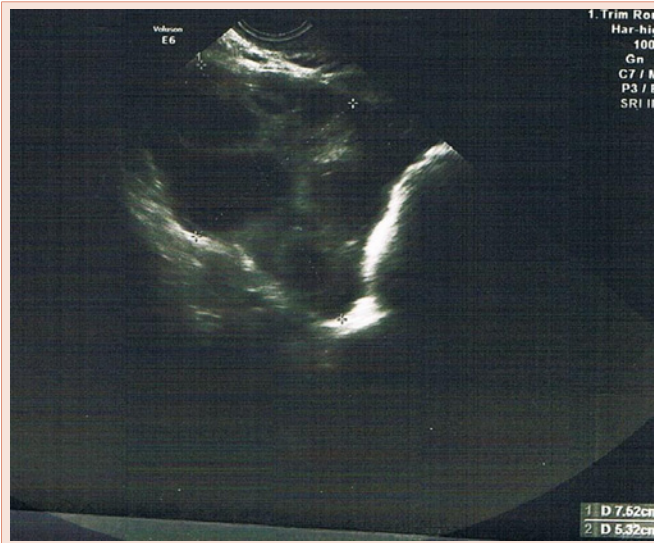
Ultrasonography scan of the patient's ovaries.
